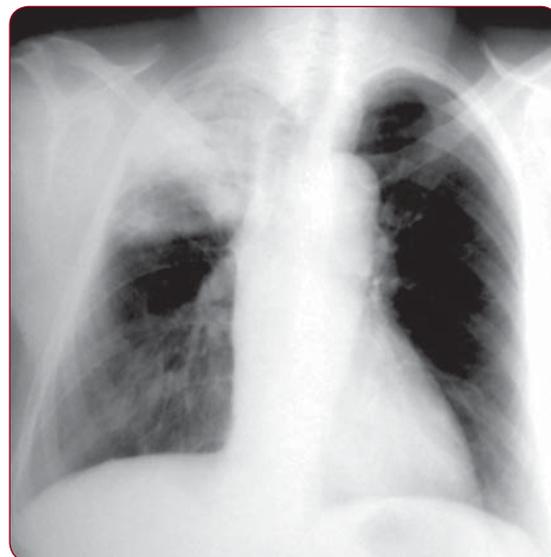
Chest radiography with right upper lobe consolidation
